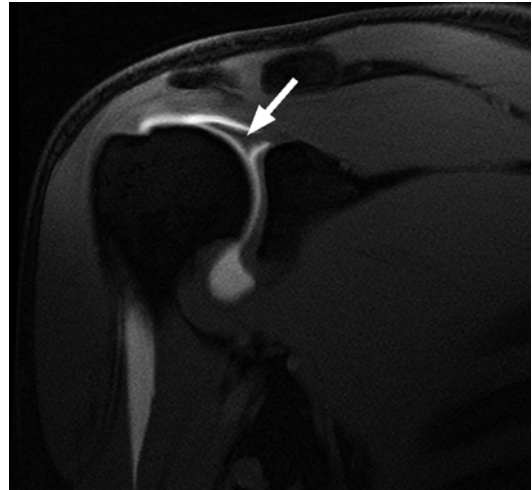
MRA of a right shoulder. Coronal oblique T2-weighted image showing a SLAP lesion (*arrow*)
